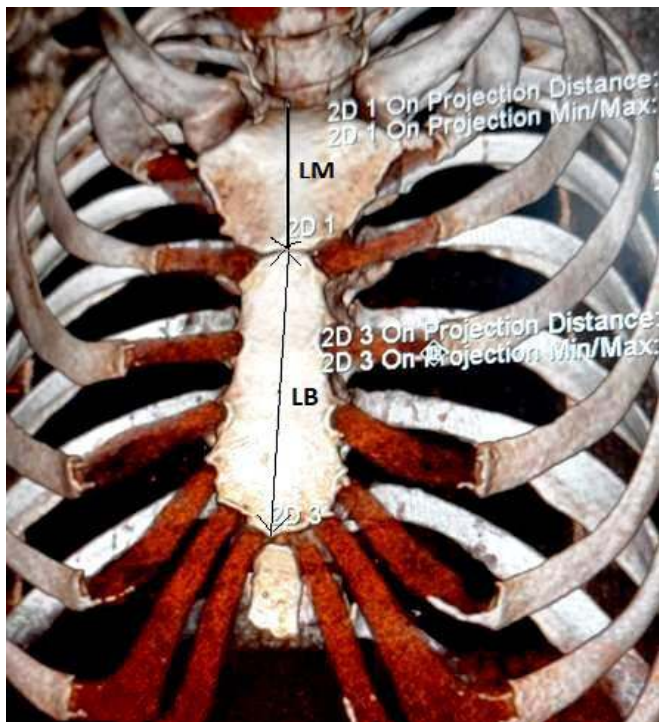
Image (128 slice MD CT Scan) of Chest showing measurements of sternum
